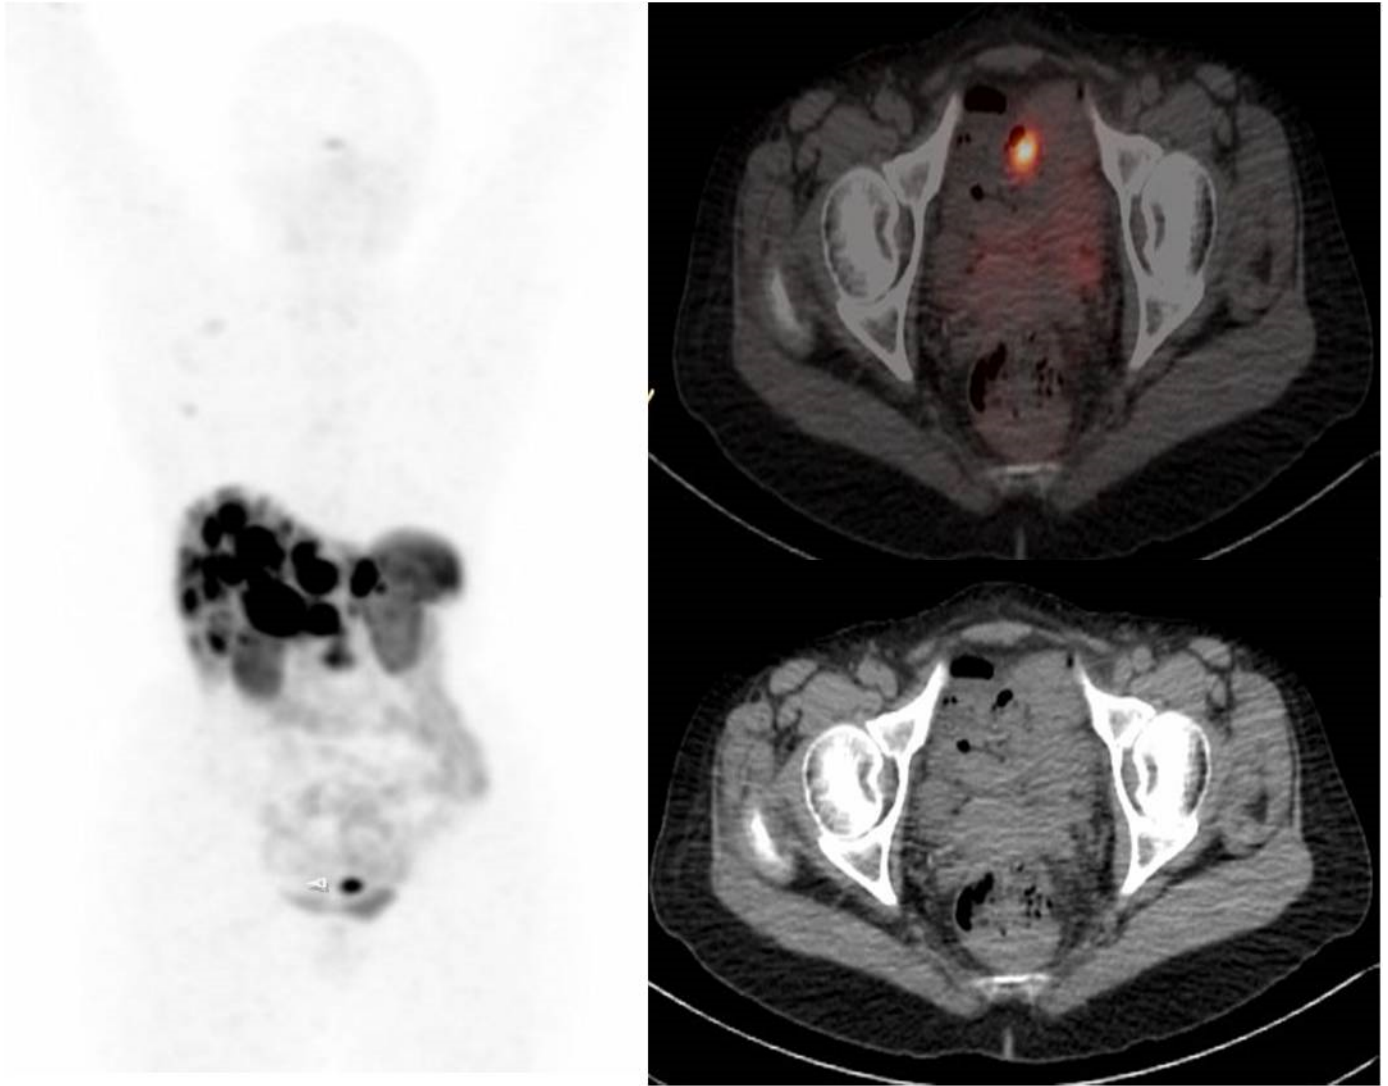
56 years old female, liver biopsy suggestive of metastatic NET of liver, Mib 1 index: <1%. The primary was undetected by conventional imaging. 68-Ga-DOTATATE PET/CT scan showing multiple metastatic liver lesions and a focal tracer concentration in the pelvic ileum. Final diagnosis: Ileal NET with bilobar hepatic metastases.
